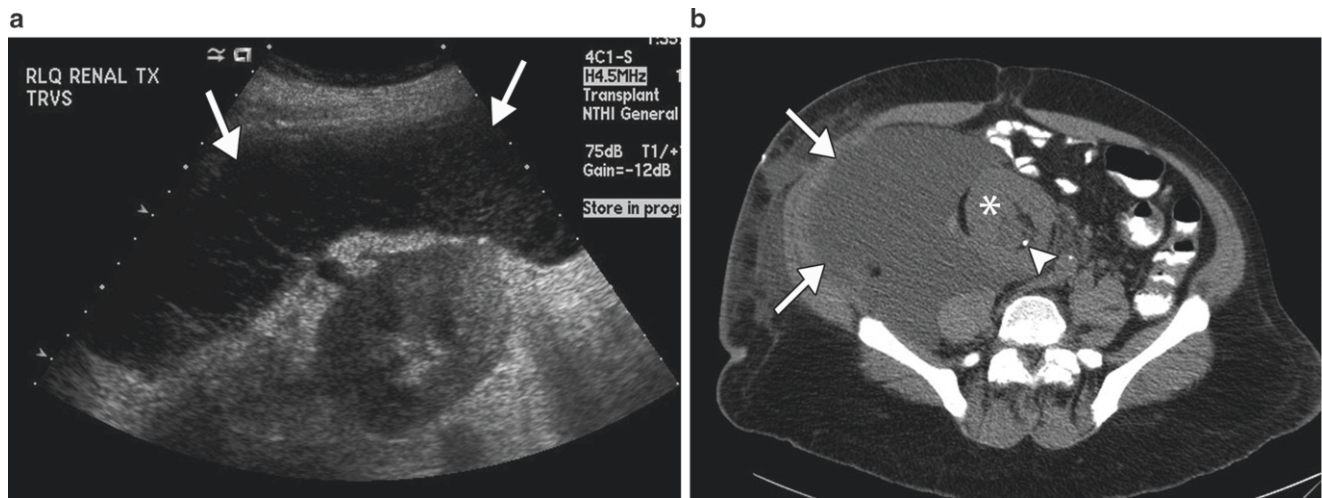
Lymphocele. (a) Ultrasound shows a large complex fluid collection (arrows) displacing the transplant. (b) Computed tomography performed with oral contrast only. There is a large fluid collection
